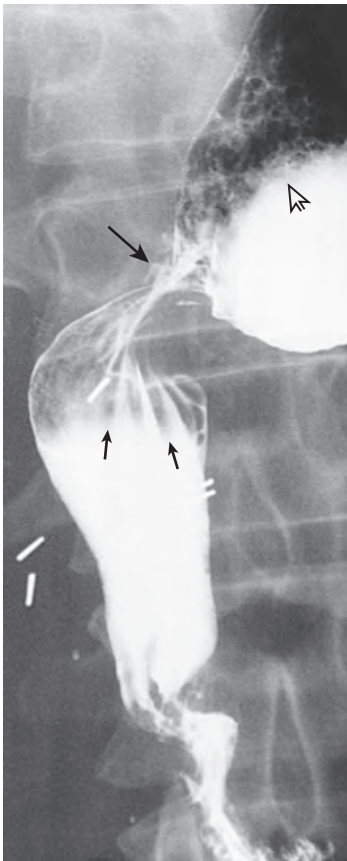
Postoperative obstruction after esophagogastrectomy. There is tapered narrowing of the stomach (large arrow) where it passes through the diaphragm. Below the diaphragm, twisting of the stomach is manifested radiographically by gastric folds (small arrows) radiating toward the area of narrowing. The stomach proximal to the obstruction shows dilation, delayed emptying of barium, and retained debris (open arrow). (From Rubesin SE, Beatty SM: *The postoperative esophagus*. *Semin Roentgenol* 39:401–410, 1994.)
